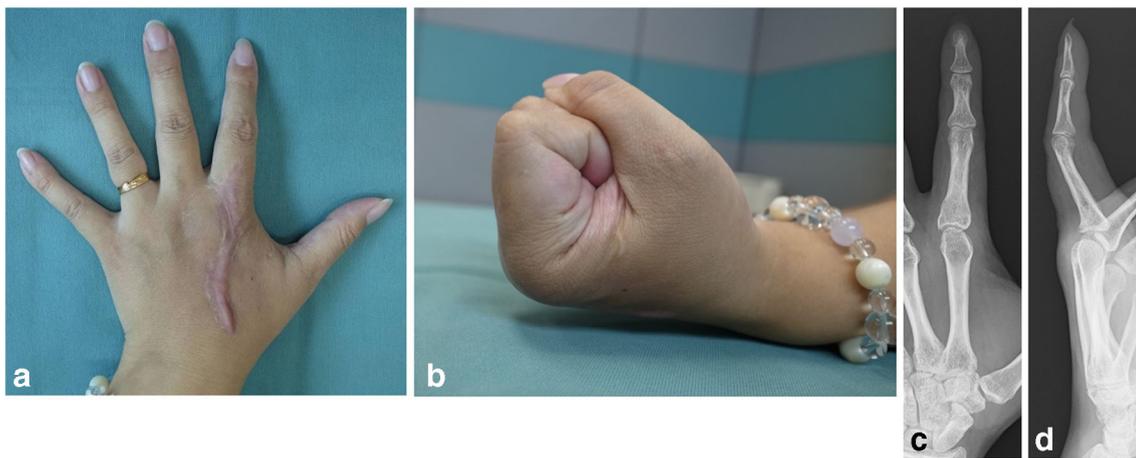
Macroscopic findings and plain radiography at last follow-up. Dorsal (a) and lateral views (b) of the left hand. Anteroposterior (c) and lateral (d) plane radiography of the proximal phalanx of the index
